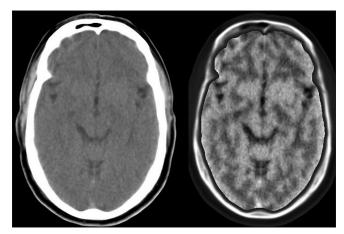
The source (left) and processed (right) CT images of first hours of stroke onset
